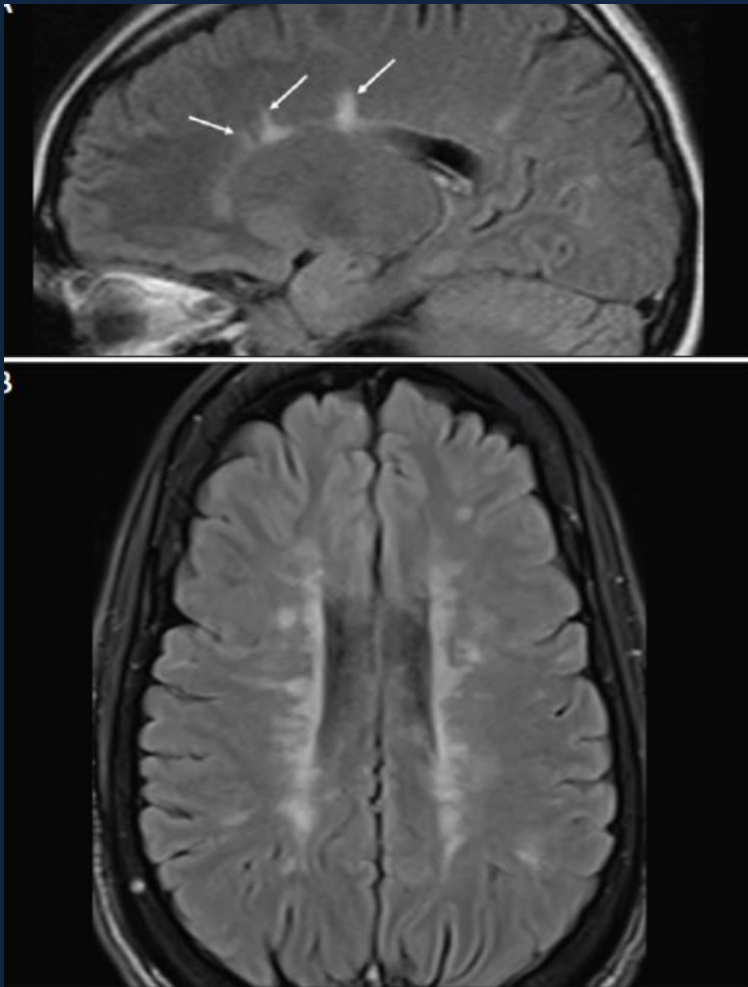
Lesions adjacent to lateral ventricle (Dawson's fingers). MRI from a patient with early MS shows a few Dawson's fingers on sagittal fluid-attenuated inversion recovery (FLAIR) image (A). MRI from a patient with more advanced MS shows numerous Dawson's fingers on axial FLAIR image (B).
